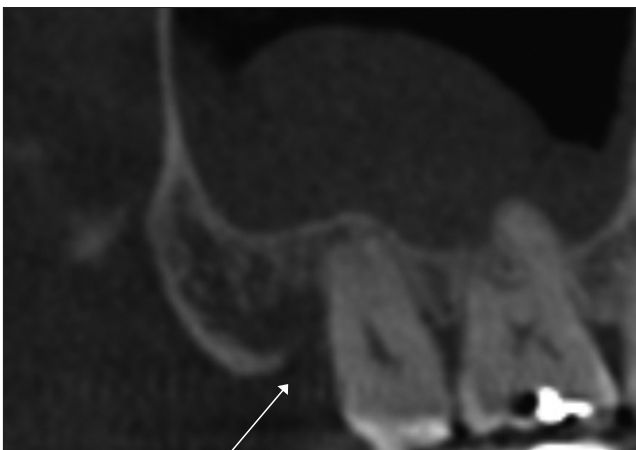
Medication-related osteonecrosis of the jaw of the maxilla. The cone beam computed tomography scan shows an irregular lytic lesion with bony sequestrum on the posterior right area of the palate (arrow).
